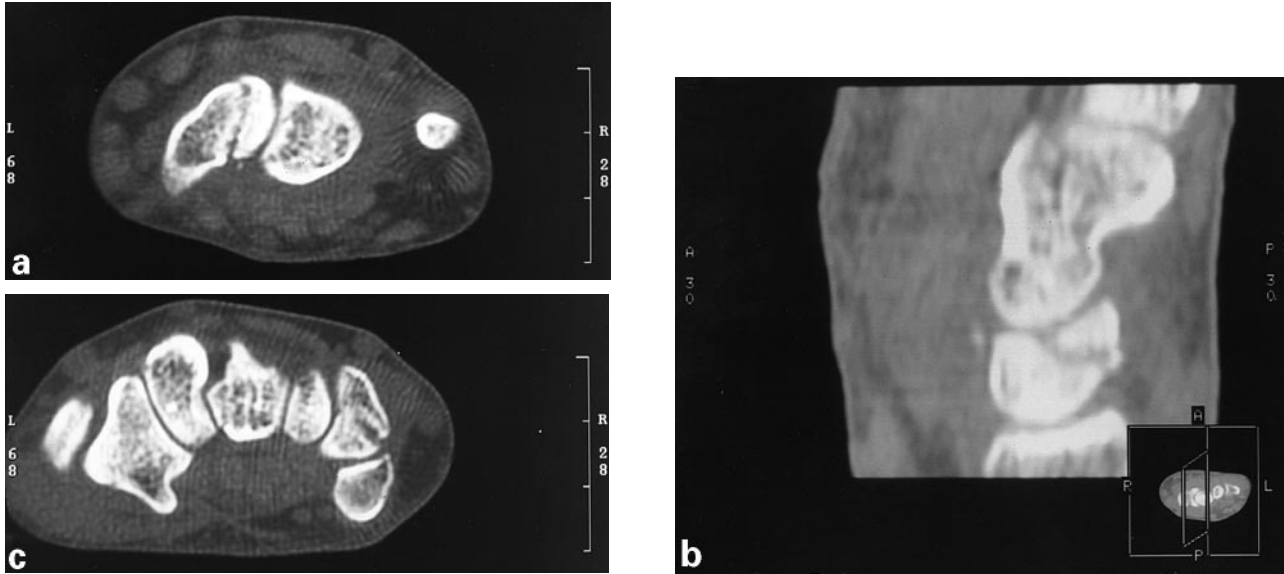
(a) CT scan showing oblique transverse fracture of the proximal pole of the scaphoid. (b) Lunate fracture in the coronal plane. (c) Triquetrum fracture in the coronal plane.
